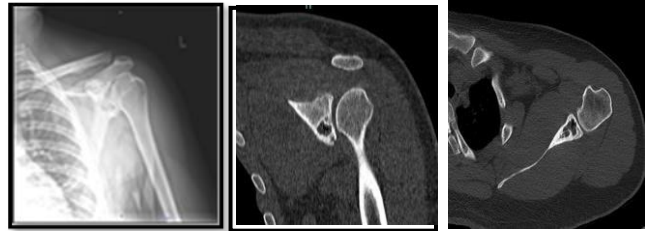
a) AP view, b & c) CT scan Left shoulder
